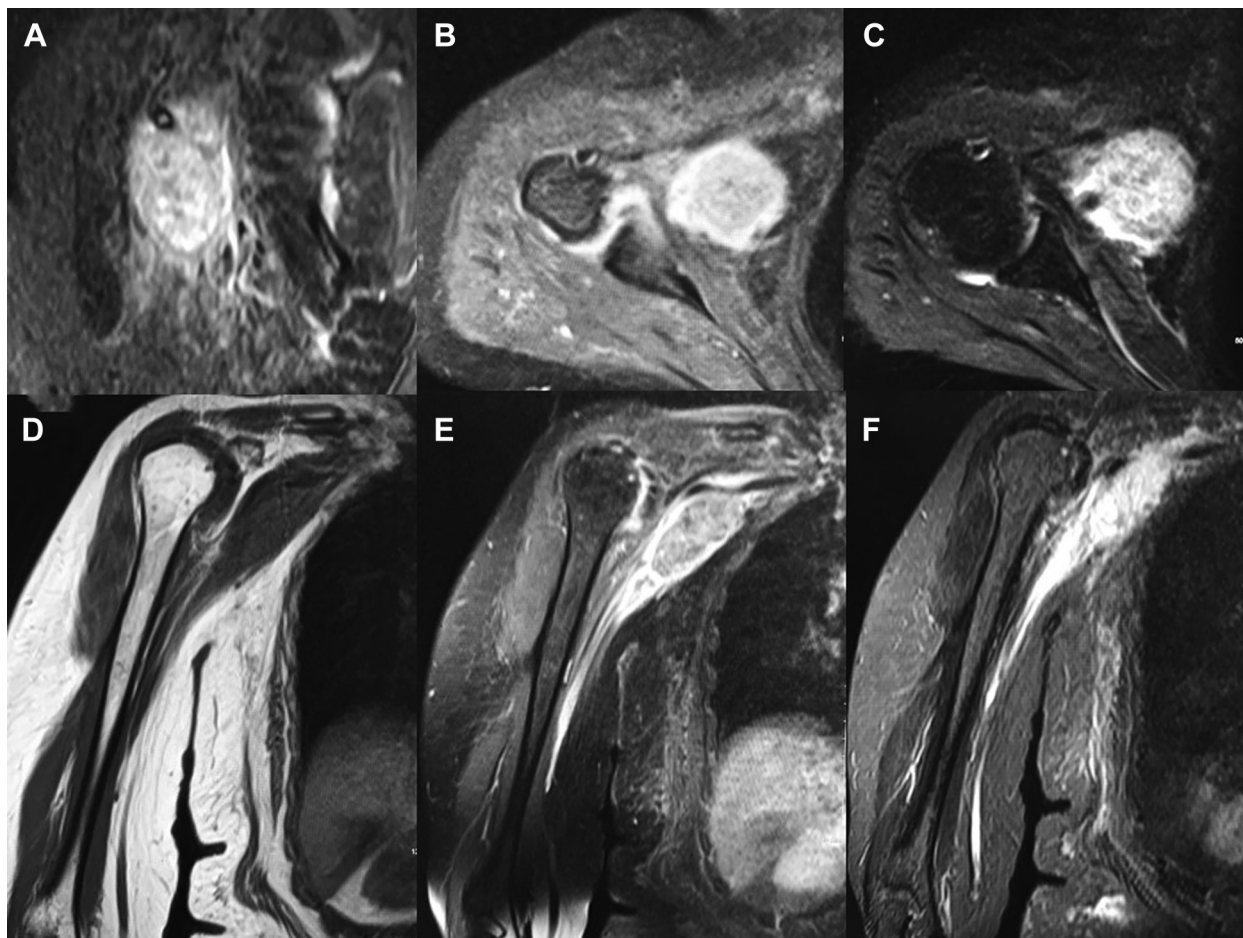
MRI images of the shoulder with and without gadolinium were obtained at multiple sequences and various planes. The sagittal short T1 inversion recovery (STIR) (A), axial T1 fat-saturated postcontrast (B), axial T2 fat-saturated (C), coronal T1 (D), coronal T1 postcontrast fat-saturated (E), and coronal STIR (F) sequences are demonstrated. The malignant peripheral nerve sheath tumor appears as a heterogenous solid mass with T1 hypointense, T2 hyperintense, and avid enhancement on postcontrast images.
